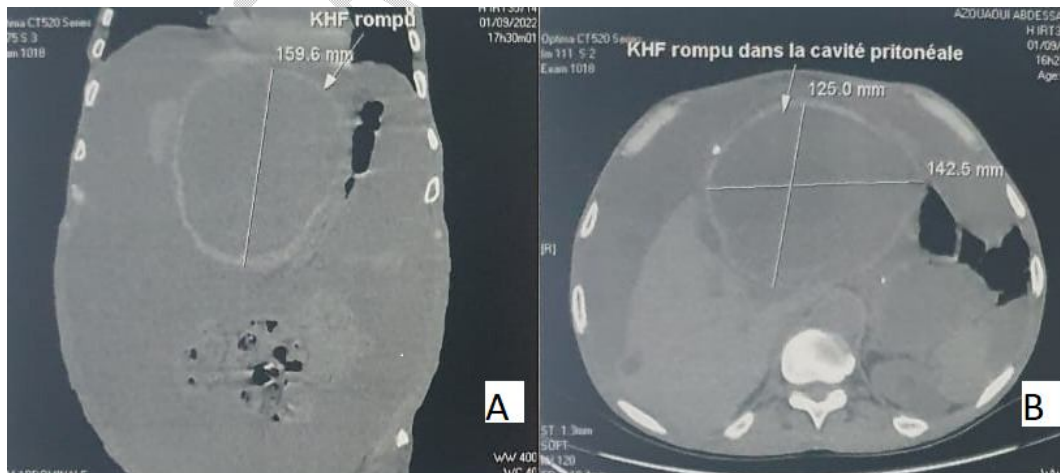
CT image showing ruptured hydatid cyst
